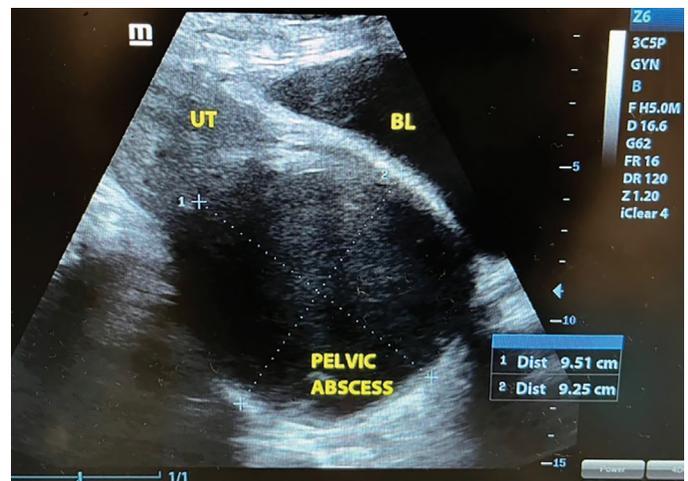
Ultrasonography image showing collection in leiomyoma
